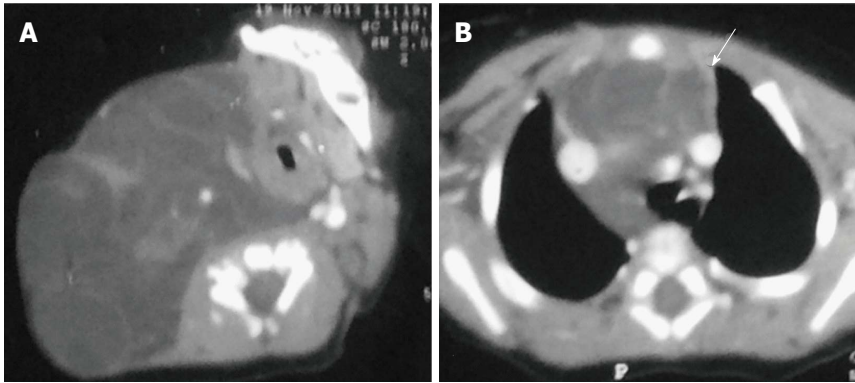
Thymic involvement by a large lymphatic malformation in a neonate diagnosed antenatally with cystic neck swelling. A: Contrast-enhanced CT scan shows a large right-sided poorly circumscribed, multiloculated low attenuation mass in the infrahyoid neck with extension into the posterior cervical and retropharyngeal space; B: Axial sections at the level of origin of arch vessels reveal involvement of the thymus (arrow) by this mass and extension into the anterior and middle mediastinum.
